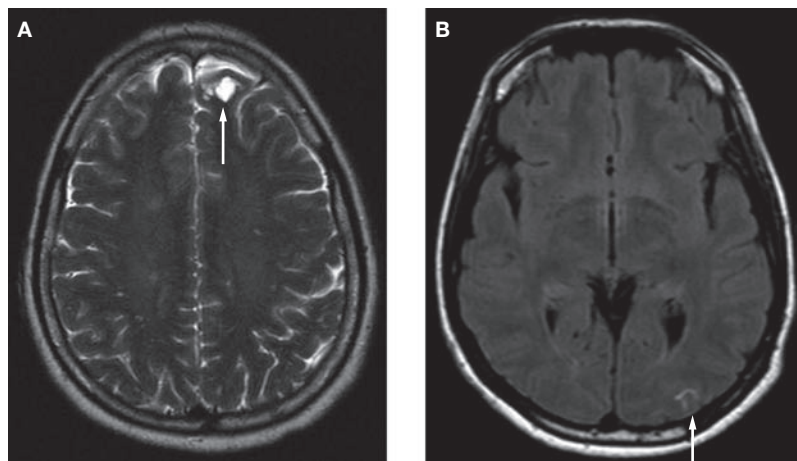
Axial MRI of the brain performed upon onset of headaches and sensorineural hearing loss. (A) T2-weighted sequence revealing cystic encephalomalacia in left frontal lobe (arrow). (B) Post-gadolinium T1-weighted sequence revealing pial enhancement in left occipital lobe (arrow).
